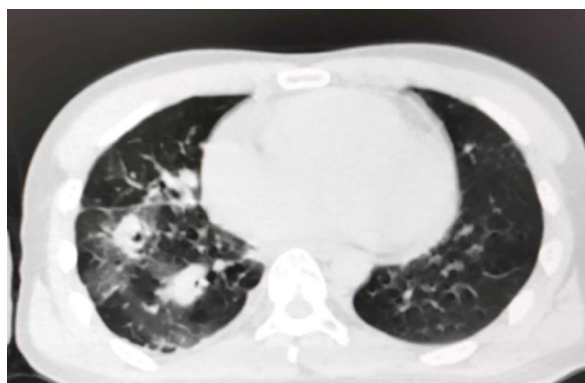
Computed tomography images revealing multiple nodules and patchy images in the right lung.
